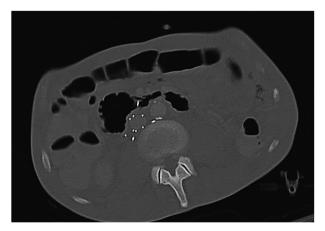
CT abdomen 2 months post implantation. Note all 4 primary filter struts outside of IVC with one of the legs penetrating into the duodenal lumen.
